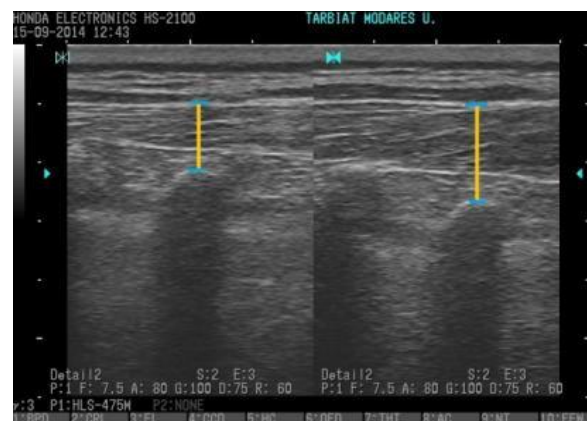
Ultrasonography image of the back extensor muscles at rest (left) and maximum contraction (right)
